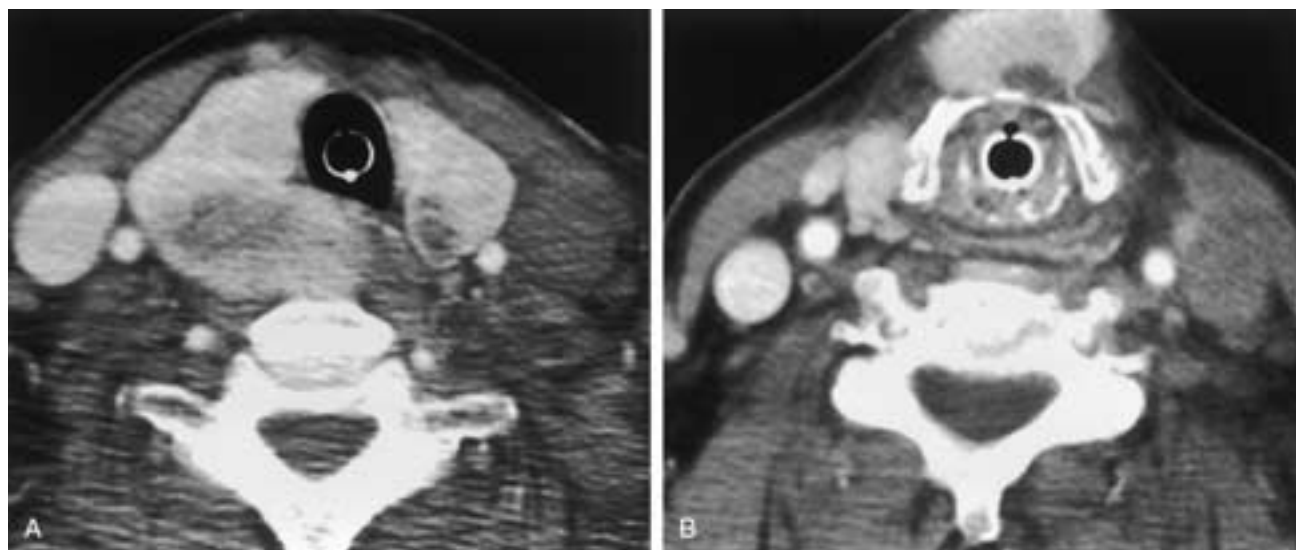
Multinodular goiter. A, Enhanced axial CT image shows asymmetry in the thyroid gland. Both lobes are enlarged (the right greater than the left), with multiple focal regions of low density consistent with goiter. B, Enhanced axial CT image superior to A shows nodular enlargement with a focal area of hypoattenuation within the isthmus of the gland. The patient has an orotracheal tube in place.
